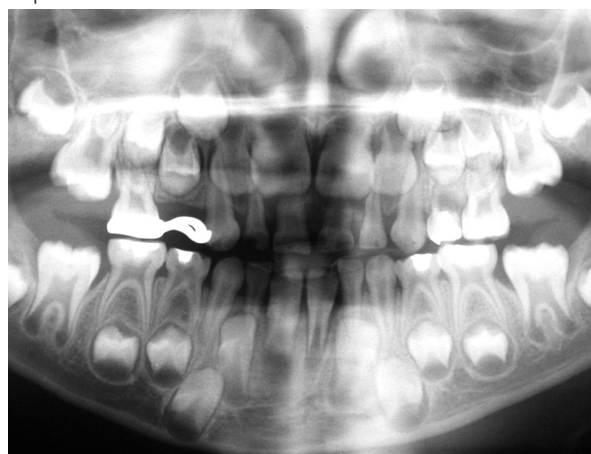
Panoramic radiograph taken two years after the operation.
